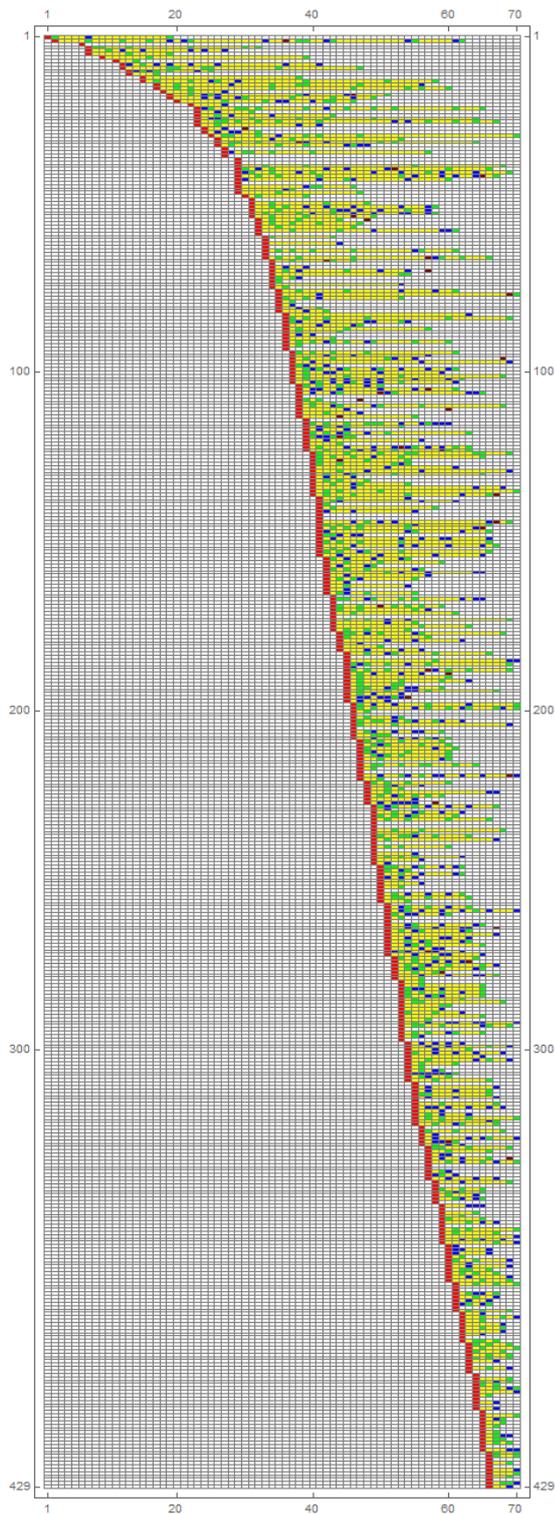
Follow-up duration matrix of all 429 patients. X-Axis: month since first IRE. Y-Axis: patient number. Red: time of IRE; green: on-site MRI and PSA follow-up on site, blue: External MRI or PSA; dark-red: recurrence found; yellow: follow-up time (see discussion section).
